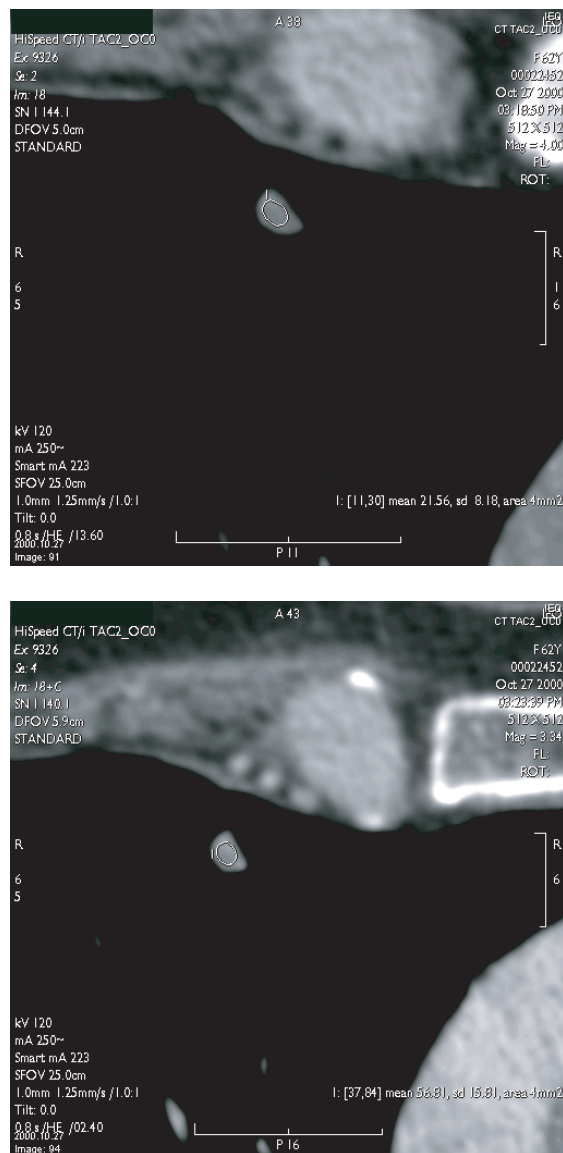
The mean density of a 6 mm solid lung nodule at pre-contrast CT scan was 21.56 ± 8 HU. One minute after i.v. injection of iodinated contrast medium the density value was 56.8 ± 15 HU. Enhancement of 35.3 HU was considered highly suspicious for malignancy and led to a surgical biopsy, followed by lobectomy, demonstrating a T1N0 adenocarcinoma.
